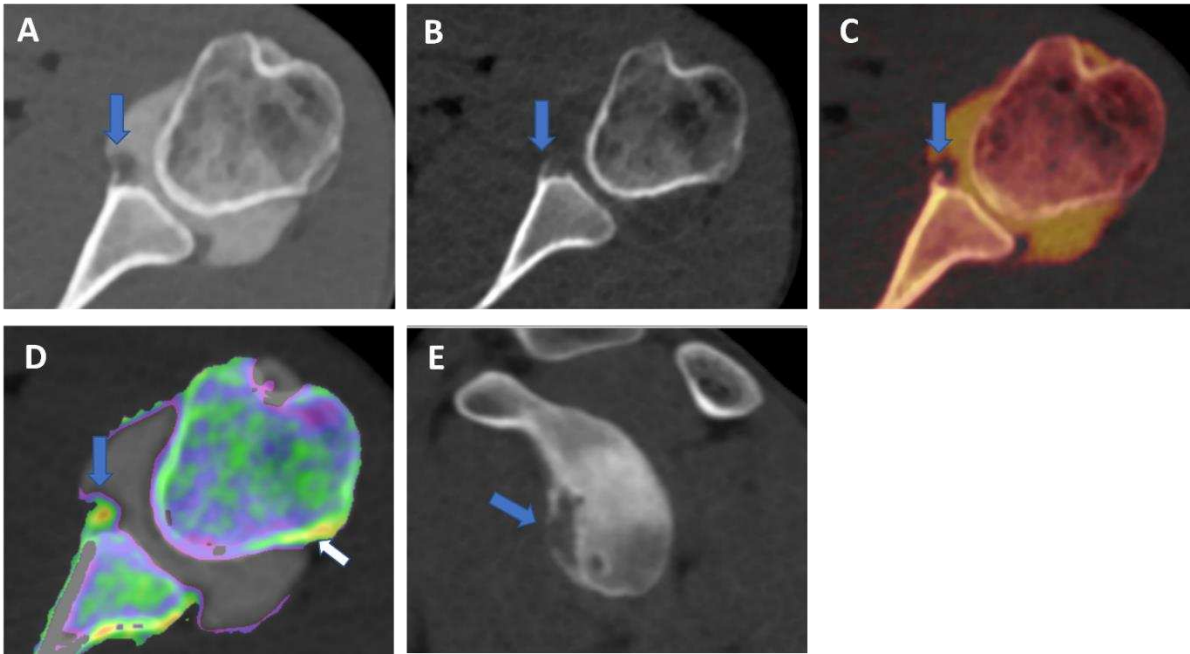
recurrent anterior shoulder dislocation in a previously operated patient. By using multiple applications, DECTA can help in the diagnosis of anterior shoulder dislocation, potentially representing a one-stop one-shop procedure. Blended virtual 120 kVp axial CTA image (A) shows anterior labral and glenoid rim disruption (arrow). VNC image on axial (B) and sagittal plane (E) helps in evaluation of bone morphology allowing correct glenoid surface measurement (arrow). In the axial iodine map (C) is possible to better evaluate the morphology of anterior labrum (arrow). In the axial BME 2D super-imposed image (D) is possible to recognize edema of the anterior glenoid rim (blue arrow) and subtle edema of the posterior aspect of humeral head (white arrow), that is consistent with recent recurrent dislocation.
